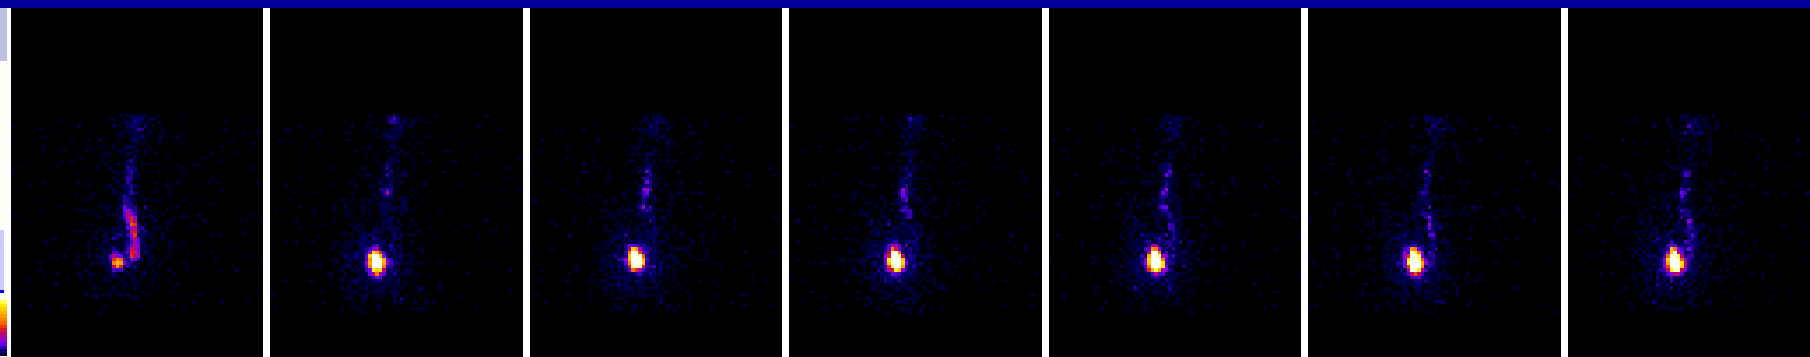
Oesophageal scintigraphy in a volunteer.
